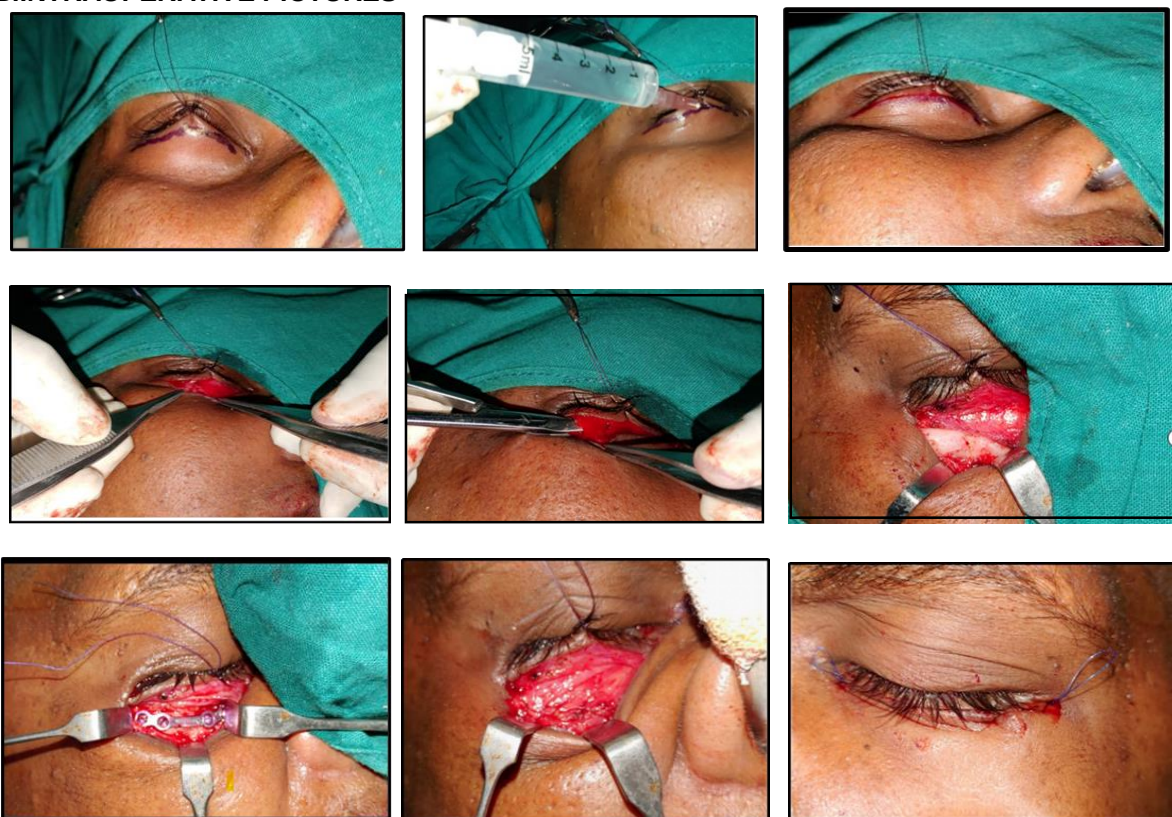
Subciliary approach to the infraorbital rim fracture. (A) 3D CT reconstruction, coronal CT section demonstrating the fracture and Post -op PA view. (B) Intra-operative sequence showing marking of the subciliary incision, the initial skin incision, suborbicularis dissection to the periosteum, fixation with a 1.5x4-hole infraorbital titanium miniplate and 1.5x6 mm screws, closure of the periosteum with interrupted sutures, and skin closure with 5-0 prolene.
